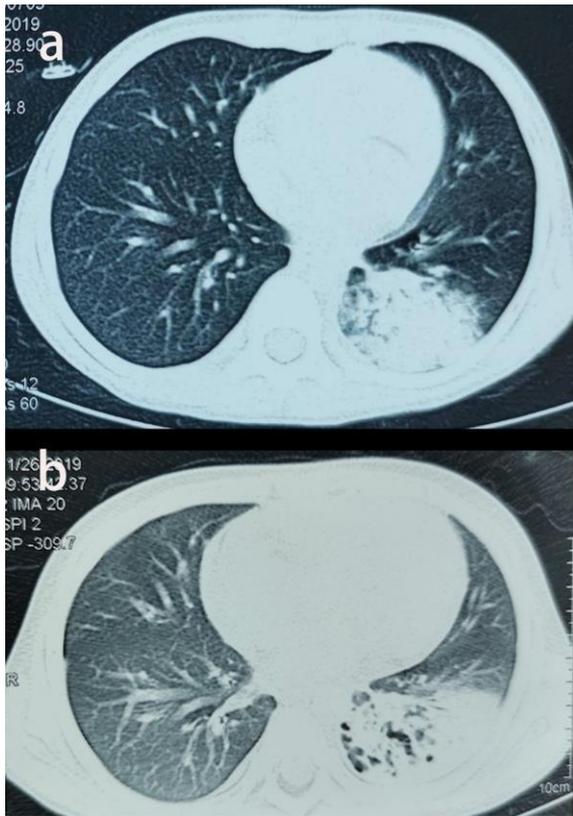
Thoracic axial computed tomography (CT) images showing high-density shadow in the left lower pulmonary lobe on admission (a), and inflammation in left lower pulmonary lobe improved with necrosis on 16th day of admission, (b).
